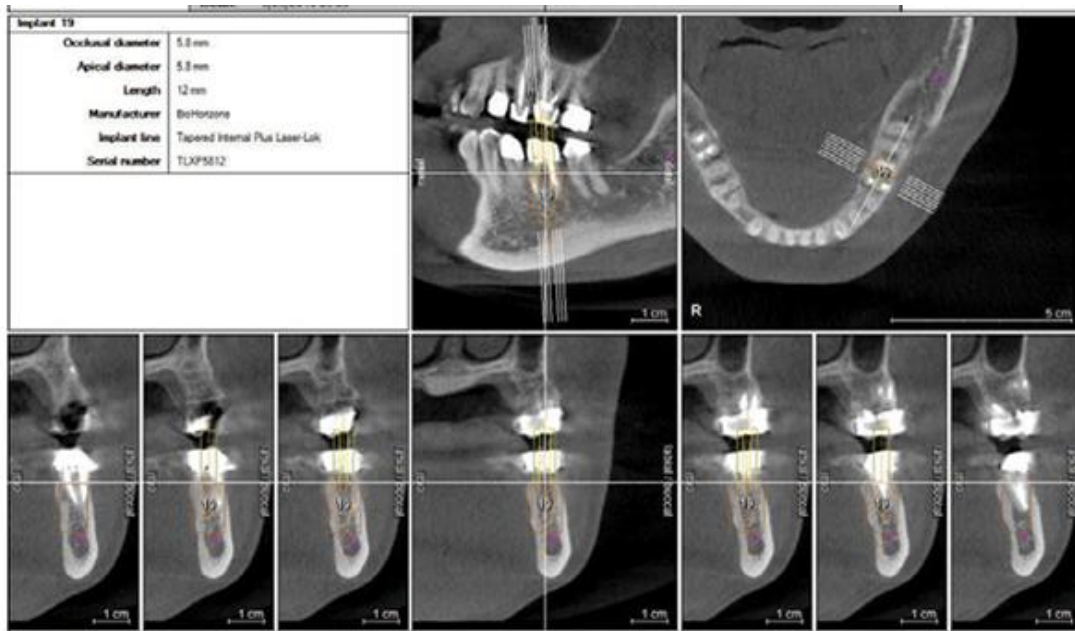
Cone Beam Computer Tomography (CBCT) of the mandible
